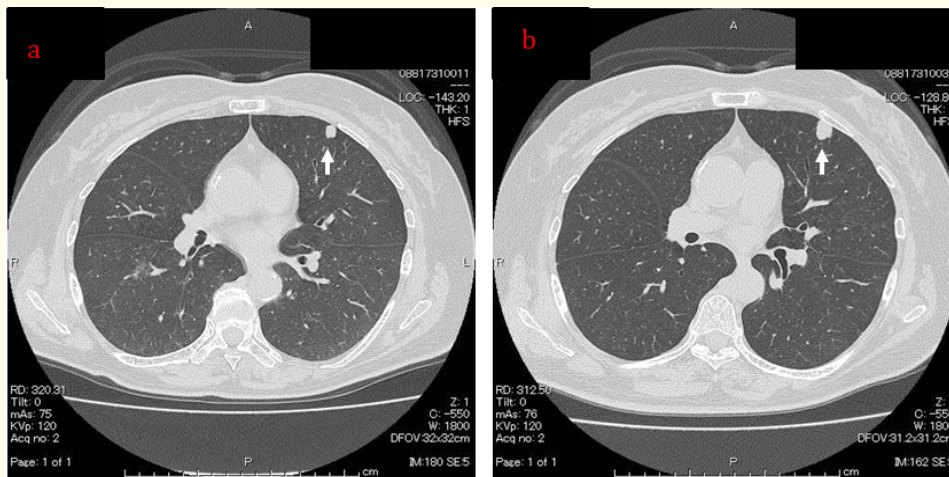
(a) CT scan of the chest showing a round, well-defined homogeneous nodule measuring 1.0 cm, which (b) slightly increased in size to 1.2 cm after 6 months.
